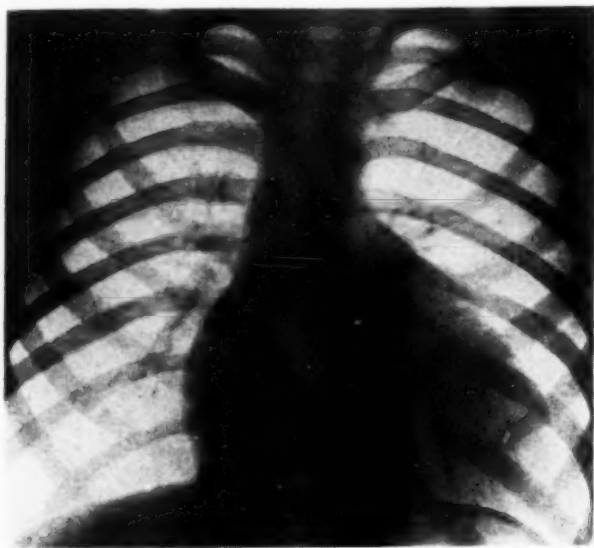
(Case 2).—Plain roentgenogram of chest. Globular heart; large right auricle; (?) large right ventricle; pulmonary arteries not enlarged, and lungs underfilled.
